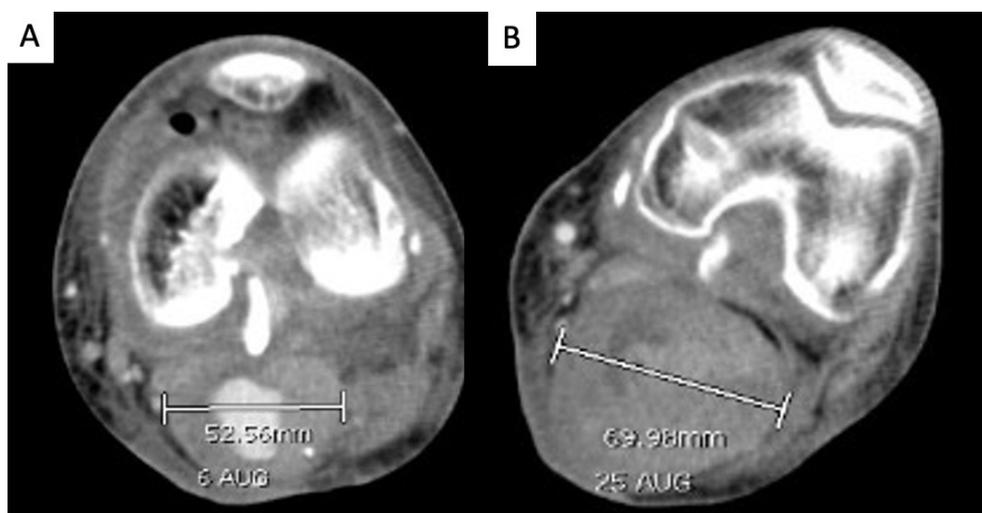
CT angiography images.
